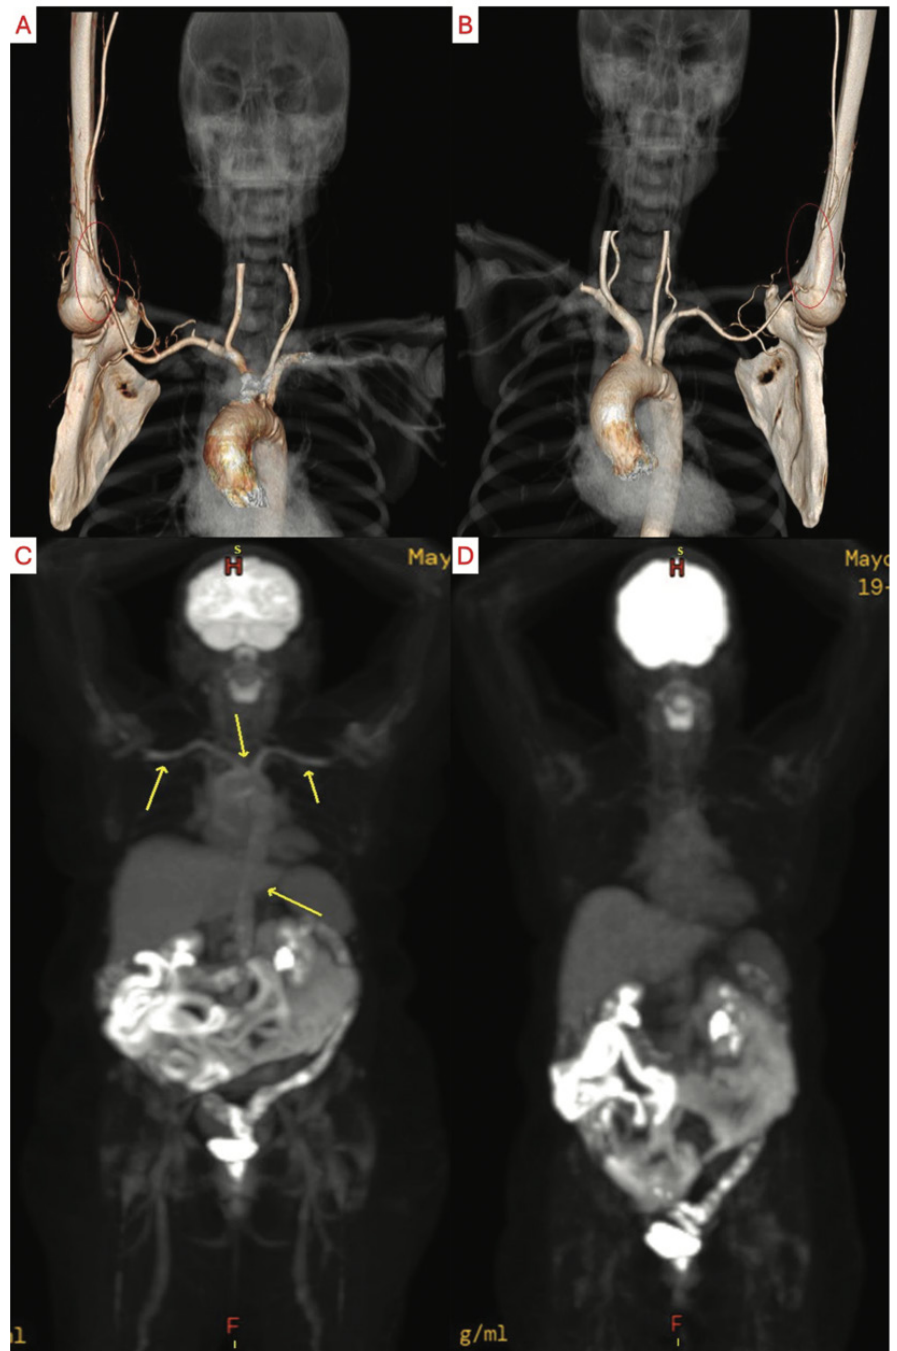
Three-dimensional reconstruction of computed tomographic angiography demonstrating high-grade stenosis of the right brachial (A) and left brachial (B) arteries. Initial combined positron emission tomography with CT (PET-CT) demonstrating mild-moderately increased hypermetabolism of the bilateral brachial and subclavian arteries, brachiocephalic artery, and thoracoabdominal aorta (C). Repeat PET-CT after ten months of upadacitinib therapy demonstrating significant interval improvement of the arterial hypermetabolism (D).
